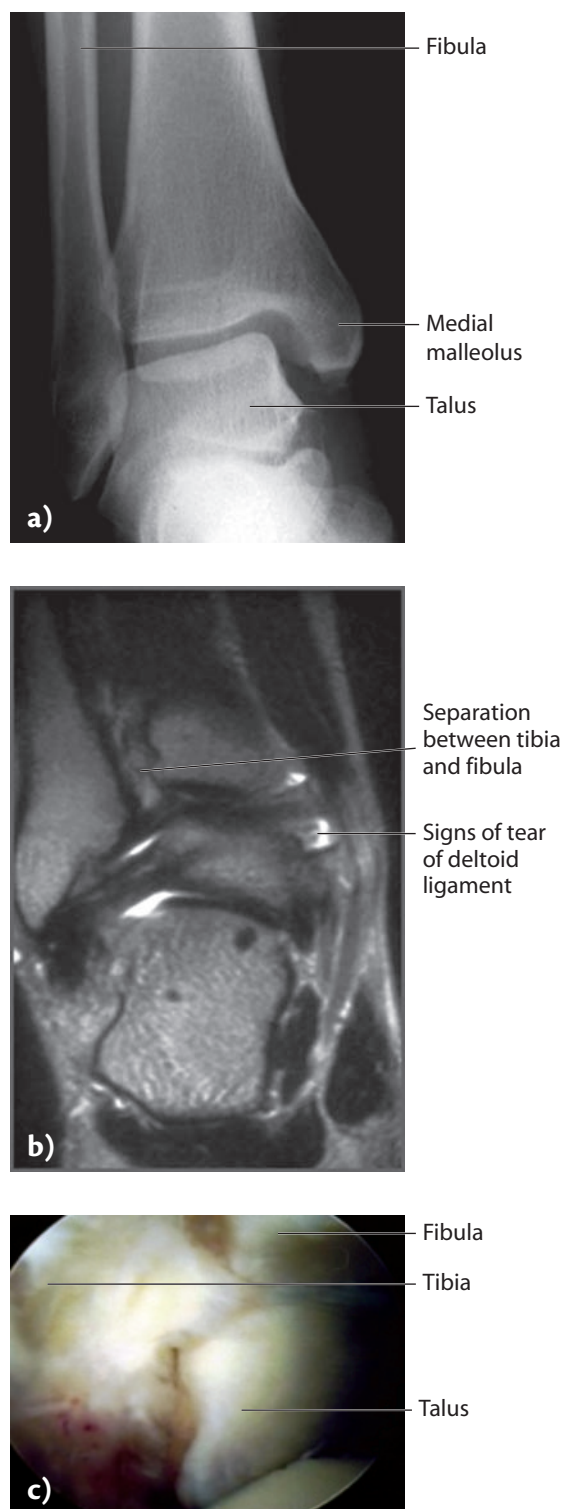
Examinations for a syndesmosis injury. a) X-ray of the ankle will show a widening of the gap between the talus and the medial malleolus; this is a sign of a rupture of the syndesmosis and should raise suspicion that there may be a tear also of the deltoid ligament on the medial side; b) magnetic resonance imaging of a syndesmosis rupture; c) arthroscopy of an ankle shows indications of syndesmotic injuries. (Courtesy of Ned Amendola, University of Iowa, USA.)
